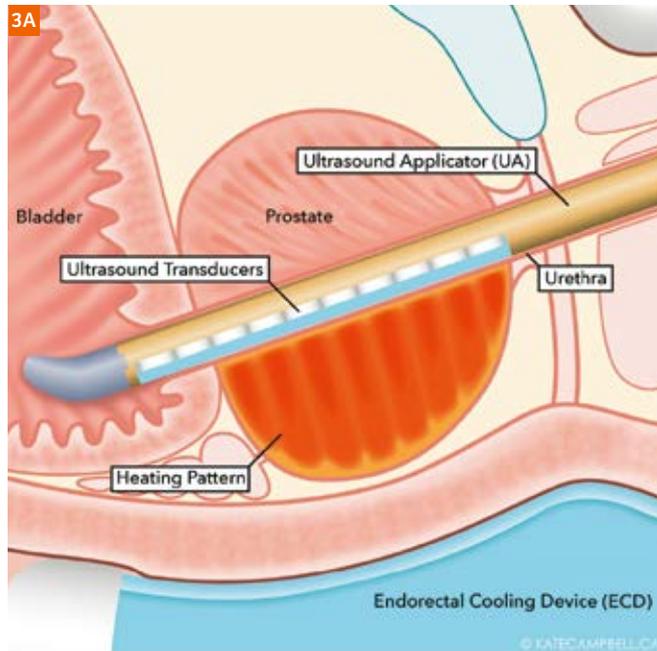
TULSA-PRO System Components. The Ultrasound Applicator, Endorectal Cooling Device and Positioning System are inside the Scanning room on the MRI bed. The Treatment Delivery Console and System Electronics remain outside the Scanning room, in the Console and Equipment room, respectively. *Figure courtesy of Profound Medical Inc.*
